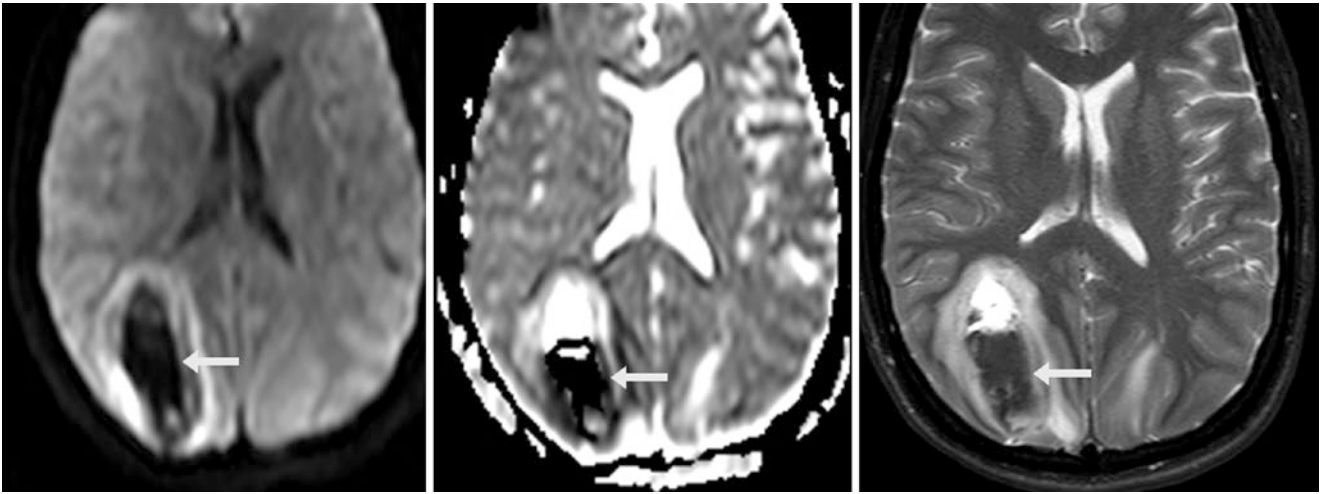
A 1.5 T MRI in a 39-year-old shows a large occipital acute parenchymal hematoma, the result of PRES in a chemotherapy patient. T2 blackout (*arrows*) results from the blood being acute age, dark on
